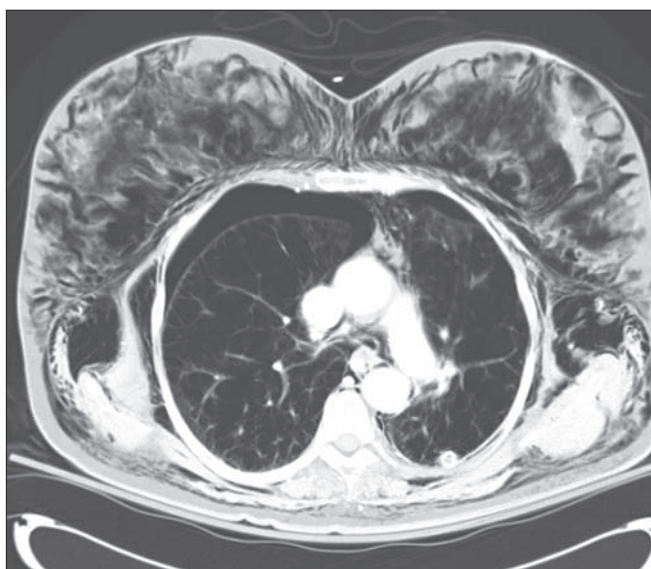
Noncontrast CT scan of chest with bilateral pneumothoraces and left shift. Extensive subcutaneous emphysema again appears in multiple fascial planes.
